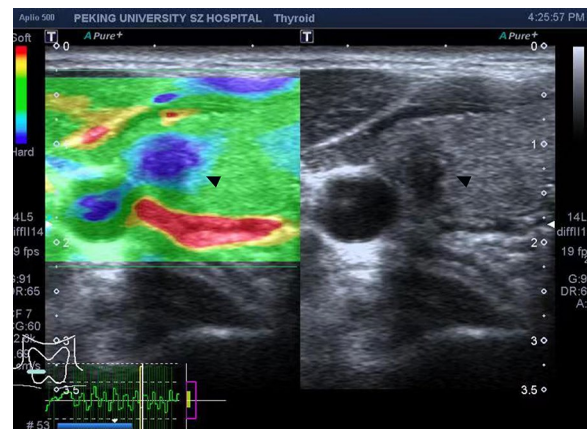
Thyroid nodule showed ES of 4. A 39-year-old male came to hospital for preoperative examination. Ultrasound image showed the entire nodule of papillary thyroid carcinoma exhibited blue was consistent with ES of 4 (marked with a black triangle). ES=elasticity score
